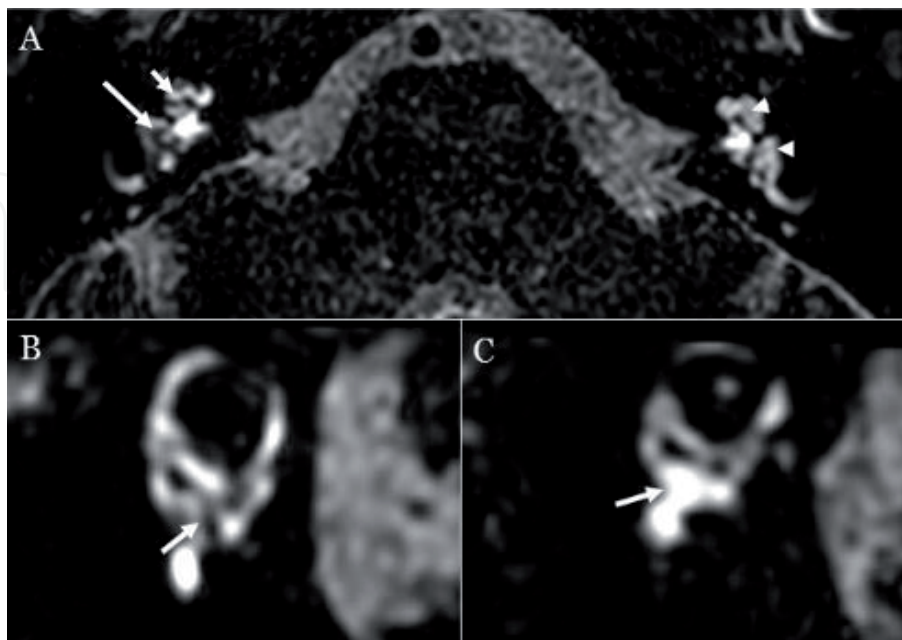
Axial 3D-FLAIR sequence after 4-h from intravenous contrast-medium administration (A) shows right vestibular (long arrow) and cochlear (short arrow) hydrops, compared with the normal left inner ear (arrowheads). On oblique sagittal plane (B), the 4-h delayed postcontrast 3D-FLAIR sequence confirms the right vestibular endolymphatic hydrops, in particular of the saccule (arrow), while in the left ear (C), the inferior third of the vestibule is normally filled by perilymph (arrow).
